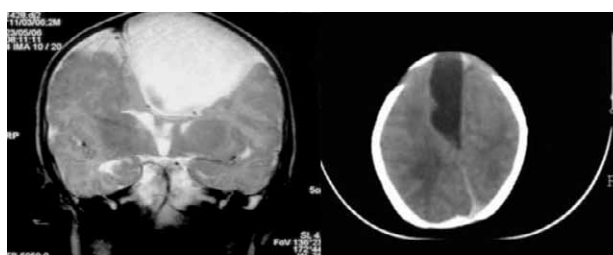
Parasagittal cyst in a 2-month old boy (left preoperative MRI; right postoperative CT scan).
